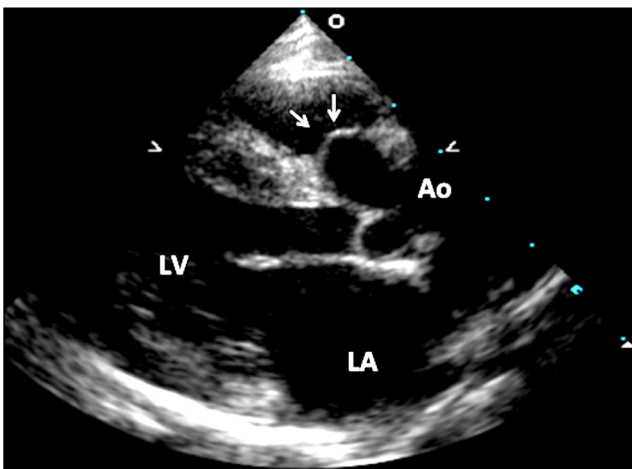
Echocardiographic image of a parasternal long axis view demonstrating enlargement and prolapse of the right aortic sinus (arrows) into a suprasternal (conal septal) VSD. The prolapsed aortic sinus obscures the VSD (Ao aorta, LA left atrium, LV left ventricle)
